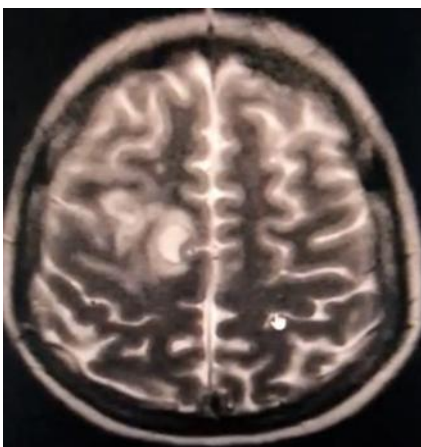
MRI Brain showing T2 hyperintense lesion resembling hemorrhagic brain metastasis.
